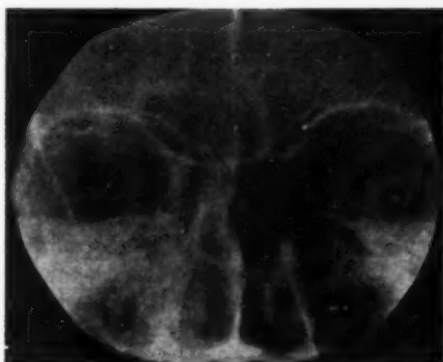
(Keeney, Kasper, and Shipman). Roentgen appearance of orbits and paranasal sinuses at time of admission.
